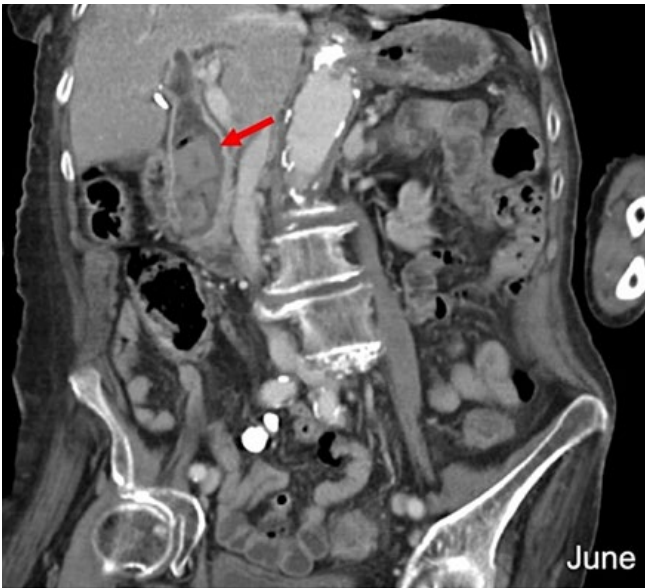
Contrast enhanced CT of the abdomen and pelvis in the coronal plane acquired in the previous month demonstrating the same gallstone (red arrow) in the common bile accompanied by other smaller calculi.
